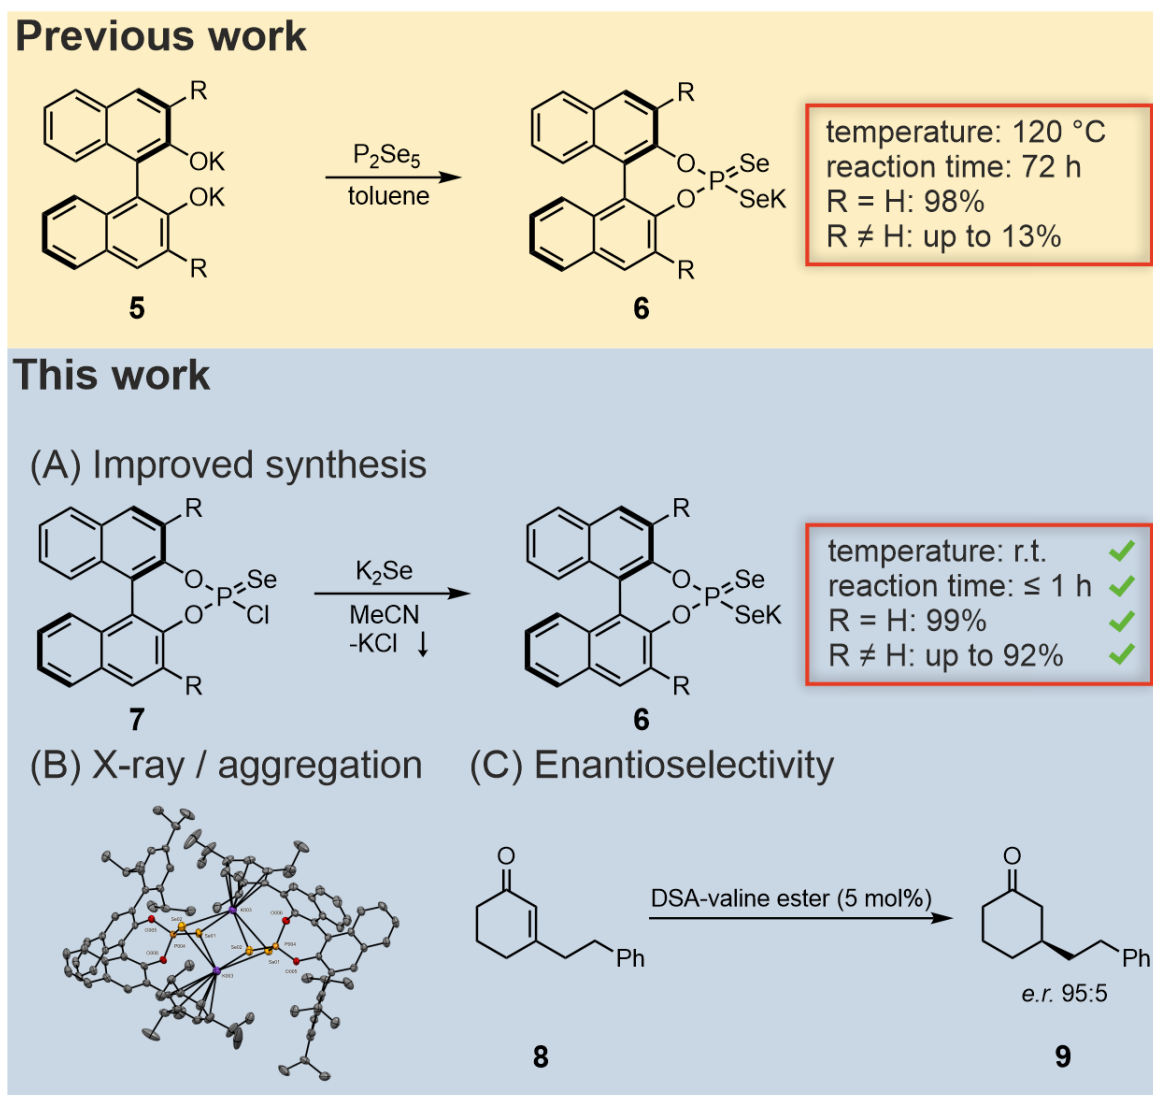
Previous work introduced a synthesis for DSA-K with R = H. This work not only improved the synthesis to mild conditions but also offers access to R ≠ H systems (A), provides X-ray data which shows dimeric aggregation (B) and incorporates successful selectivity studies of DSA-catalysts (C).
